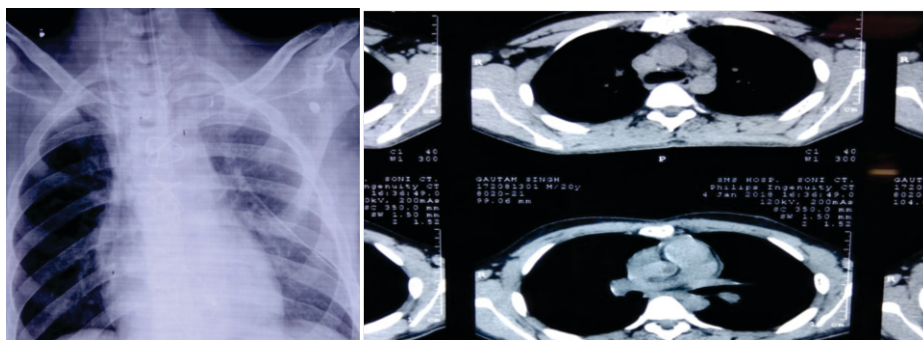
showing post operative Chest Xray and CT chest of the patient after 2 years
